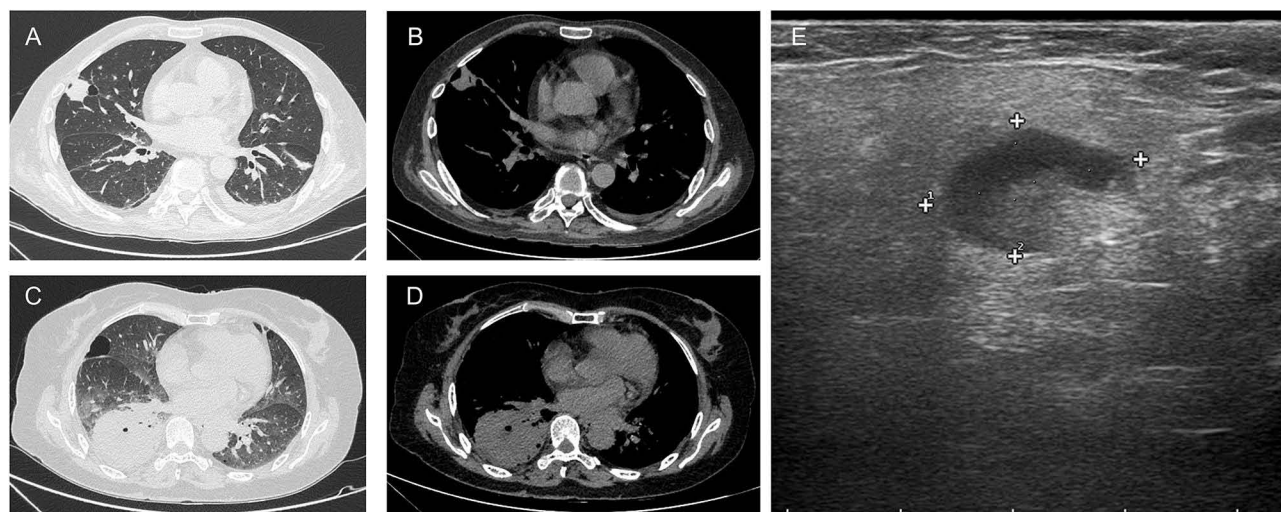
(A) Lung window and (B) mediastinal window settings from a computed tomography (CT) scan of Case 2: Infectious lesion in the right lower lung lobe with abscess formation, slightly enlarged right hilar lymph nodes, small bilateral pleural effusions, and multiple pulmonary pneumatoceles in both lungs. (C) Lung window and (D) mediastinal window settings from CT scan of Case 1: Infectious lesions at the right hilum and the lateral segment of the right middle lobe, with a right pulmonary bulla; chronic inflammatory foci in both lower lungs; multiple enlarged lymph nodes in the mediastinum; small bilateral pleural effusions. (E) Lymph node sonography of Case 1: A 20*12 mm hypoechoic lymph node with centrifugal homogeneous hypo-enhancement is observed in the left subaxillary region. The four cross marks (“+”) on the image indicate the outermost boundaries of the lymph node (leftmost, rightmost, uppermost, and lowermost points).
